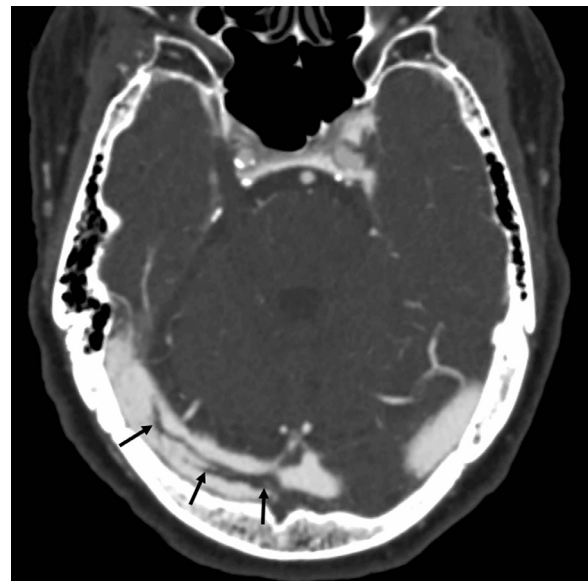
Axial CT venogram image demonstrates a curvilinear filling defect (arrows) within the right transverse sinus extending from the torcular Herophili, consistent with non-flow limiting thrombus.
